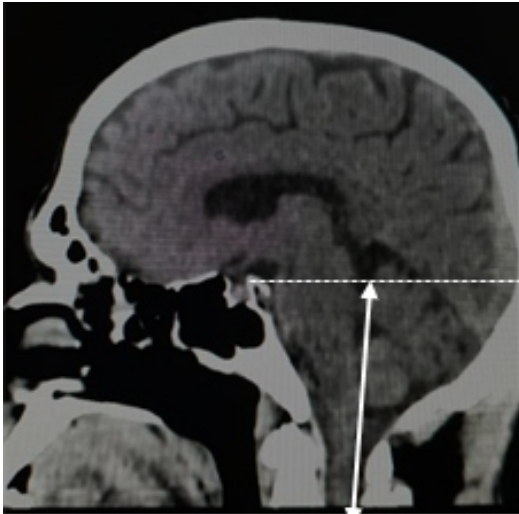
The procedure of obtaining the measurement of Klaus' height index in a sagittal reconstructed CT image of the brain. (Dotted line: the line defining the highest point of the posterior fossa; arrowed line: the measurement obtained from the tip of the odontoid process to the highest position of the posterior fossa).
